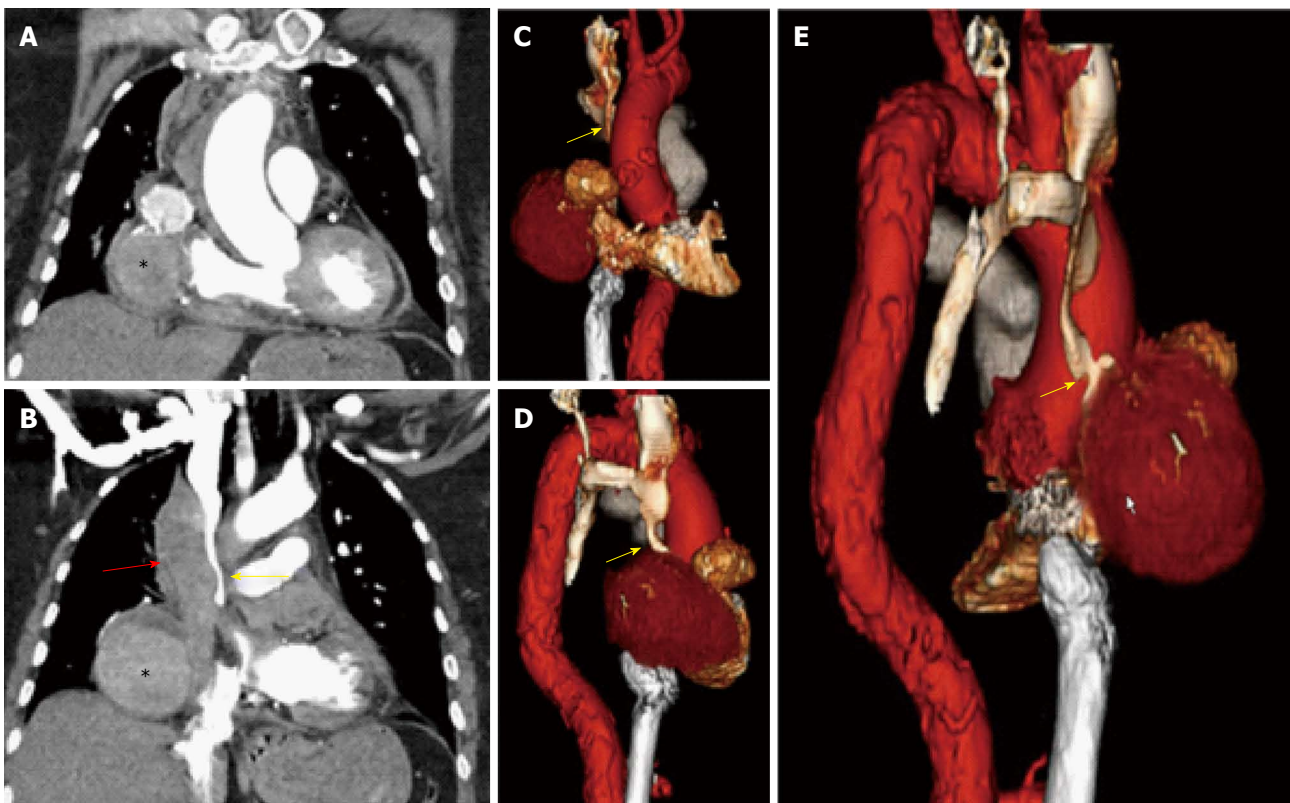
Significantly distended neck veins secondary to compression of the superior vena cava by the giant saphenous vein grafts pseudoaneurysm to right posterior descending artery. A: Coronal tomographic views showing upper and lower lobes of the SVG pseudoaneurysm (asterisks); B: Large hematoma (red arrow) is shown compressing the SVC (yellow arrow); C, D, E: Computed tomographic 3-D reconstruction of the SVG giant bilobed pseudoaneurysm and SVC compression (yellow arrow) in anterior, lateral and posterior views. SVG: Saphenous vein grafts; SVC: Superior vena cava.
